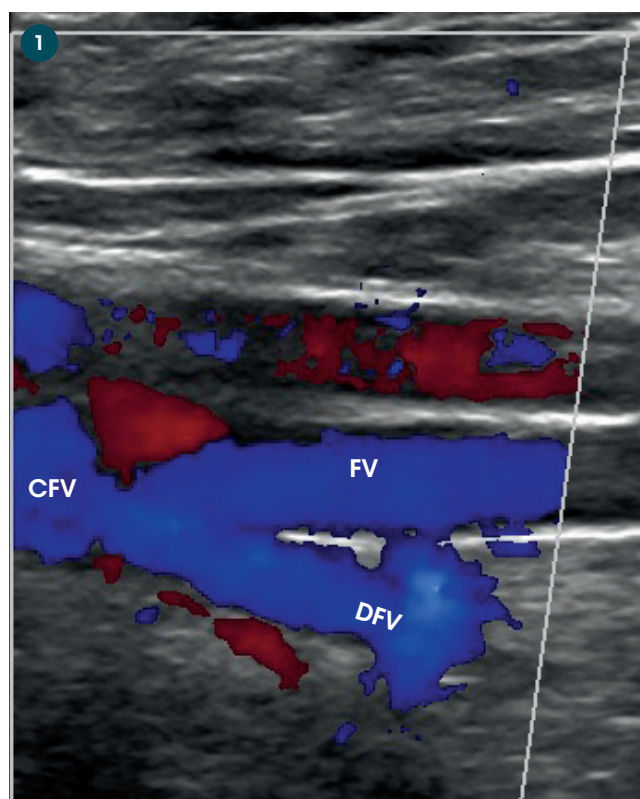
Preoperative duplex-ultrasound showing good inflow over patent femoral vein (FV) and deep femoral vein (DFV) draining into postthrombotic common femoral vein (CFV).
